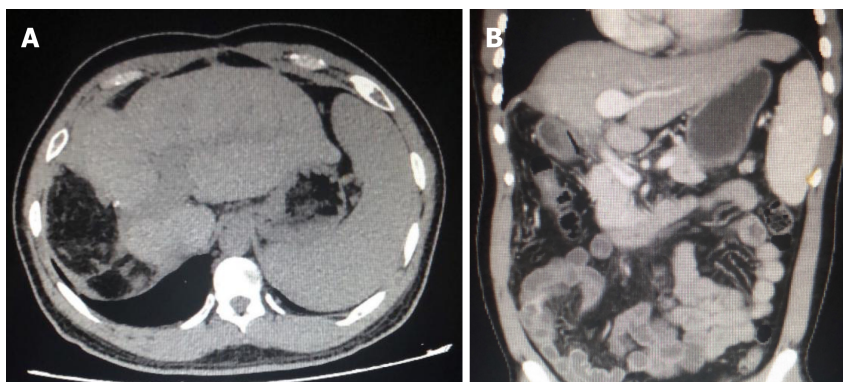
Twenty-month follow-up computed tomography images indicating no recurrence of tumor. A and B: Computed tomography (CT) transverse (A) and coronal (B) images obtained in August 2018.
